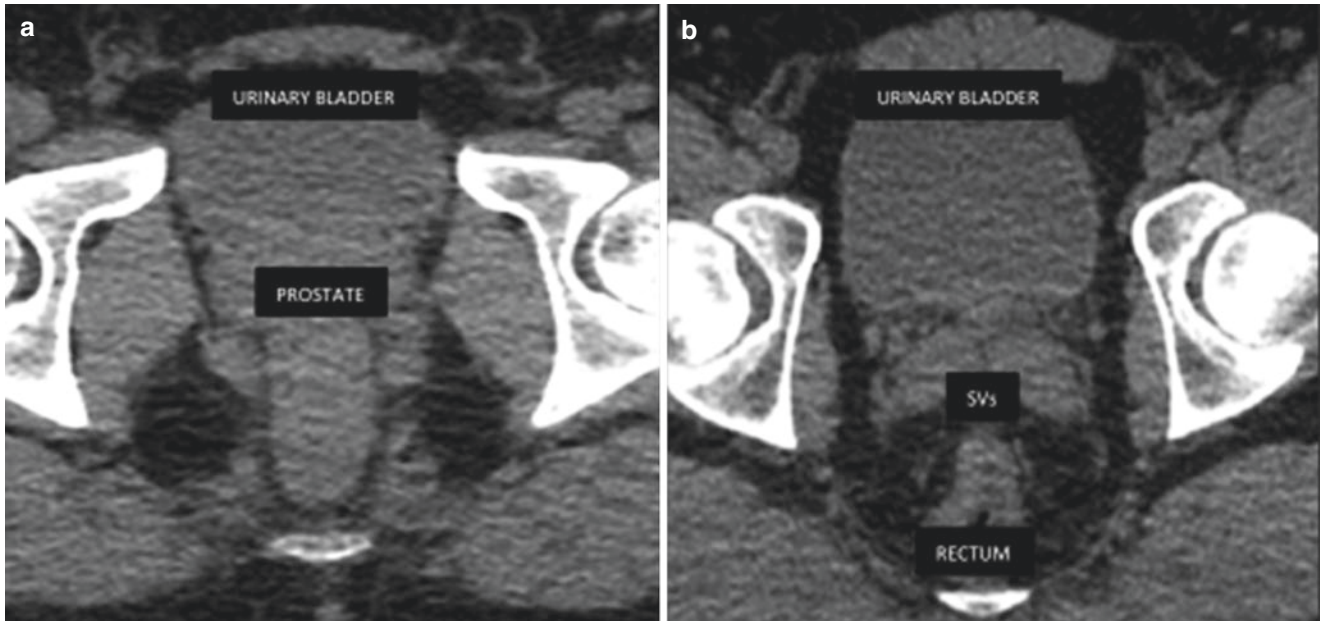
Anatomy of the prostate, seminal vesicles and vas deferens. (a,b) Axial CT image. CT noninvasive modality, identifying calcifications, soft tissue masses or cystic lesions, but radiation involved
